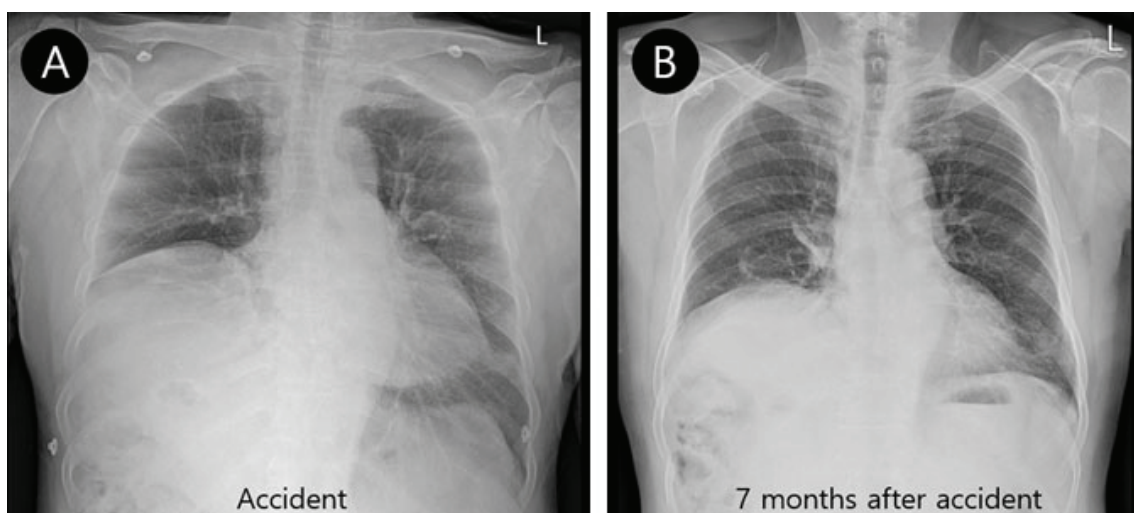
(A) Chest radiograph at admission shows that the trachea was deviated to the right of the midline and an elevated right hemidiaphragm. (B) Chest radiograph taken 228 days after onset continued to show an elevated right diaphragm, although the new radiograph reflected mild improvement since the previous chest radiograph was taken. The new radiograph also showed that the trachea was deviated to the right of the midline.
